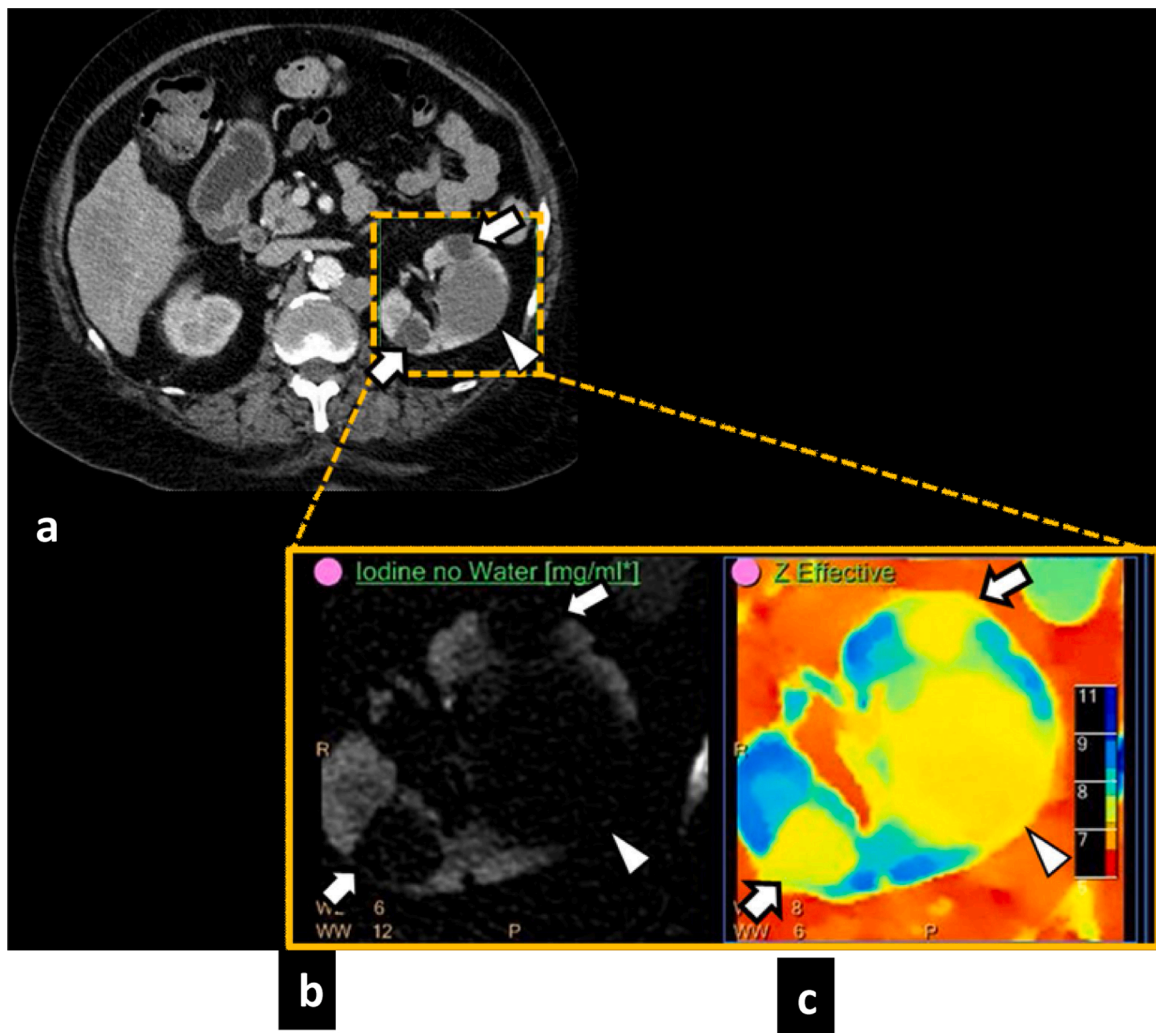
Incidental lesion assessment with DECT. A 80-year-old male was scanned as part of the pre TAVI (Transcatheter Aortic Valve Implantation) work up. Axial CT image (a) demonstrate incidentally noted hypodense (white arrows) and hyperdense left renal lesions(blue arrow), which were without iodine accumulation on iodine density (b)and Z effective images(c), consistent with hemorrhagic and non-hemorrhagic renal cysts.
